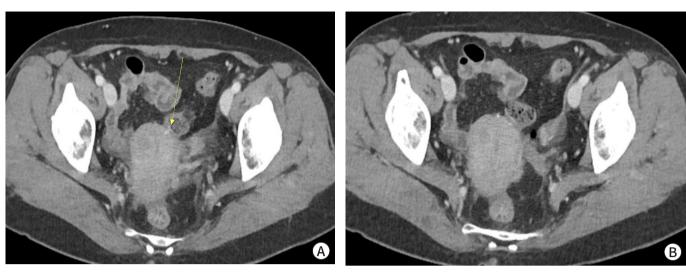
Pelvic CT findings. (A) A radiopaque foreign body was probably penetrating the uterus and abutting the sigmoid colon (yellow arrow). (B) There was no free air and fluid collection around the penetrated site.
